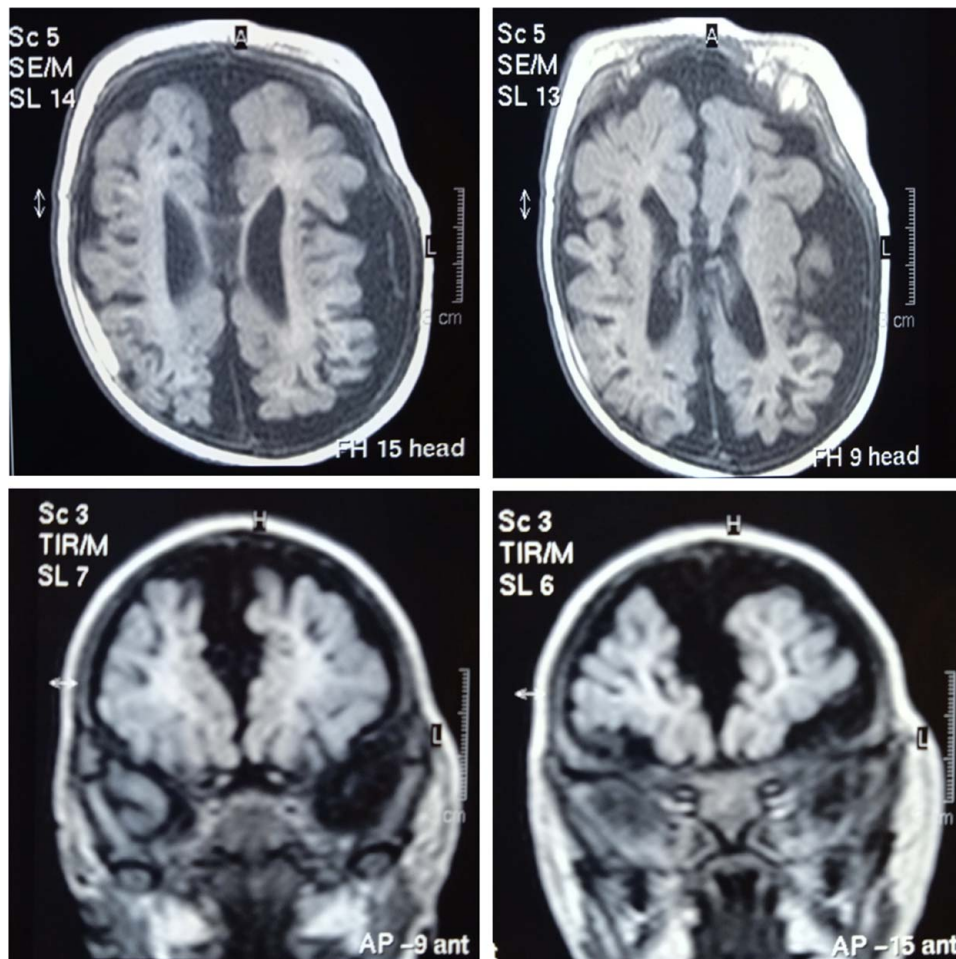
MRI revealed an atrophy in the cortex and white matter of the cerebral hemispheres, as well as dilation of the subarachnoid space and lateral ventricles.
